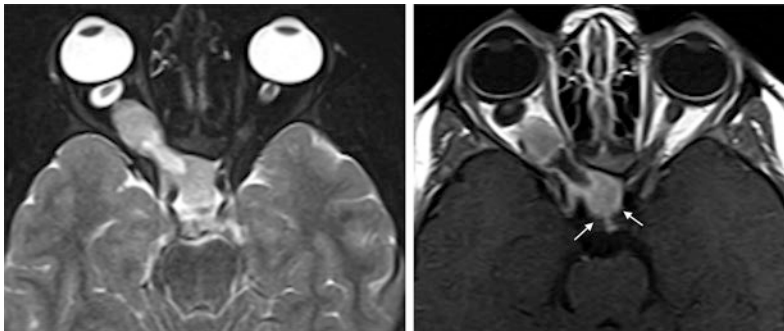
Optic nerve glioma with chiasmatic extension on MR imaging. a, b Axial T2WI and post contrast T1WI MR images demonstrate right optic nerve oblong shaped lobulated heterogeneously enhancing mass extending through the widened optic canal into the right side of chiasm (arrows)
